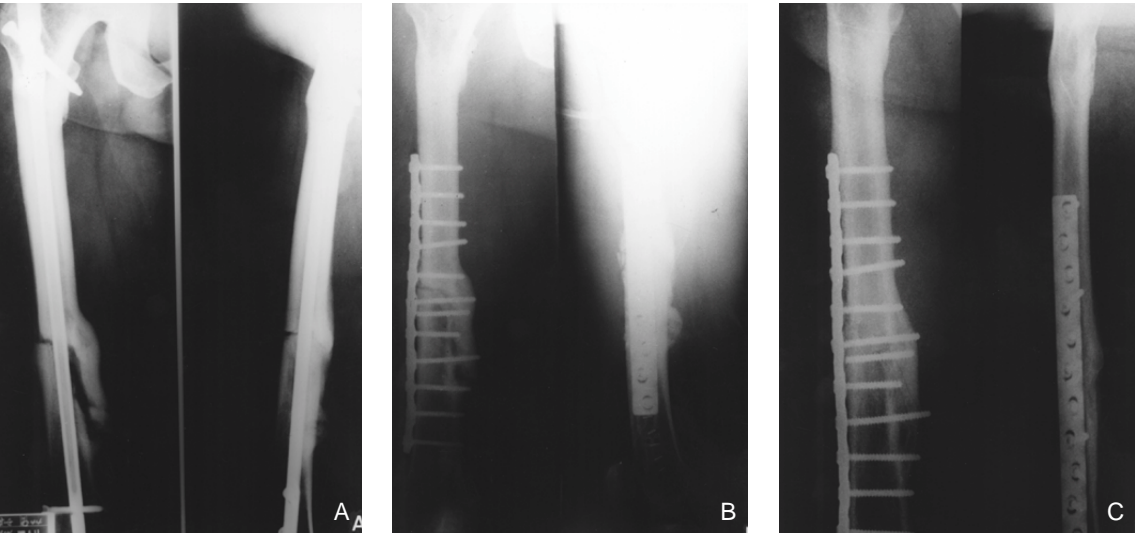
The preoperative radiograph of 48 year-old man with nonunion of femoral shaft fracture shows incompletely united fracture fragment and large fracture gap.
